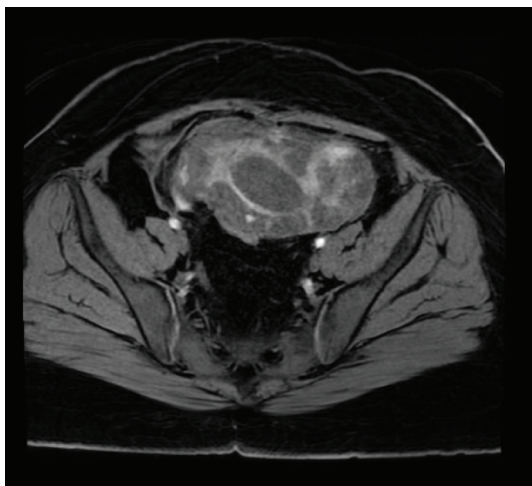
Axial pelvic magnetic resonance image demonstrating a large heterogeneous anterior pelvic mass, predominantly left-sided. It abuts the sigmoid colon without evidence of invasion and exerts mass effect on the urinary bladder with preservation of intervening fat planes.
